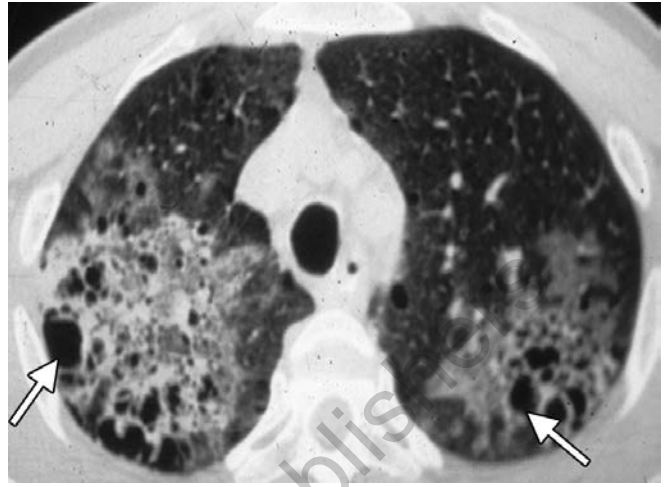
HRCT through the upper lung zones showing a dense opacity in the right upper lobe, ground glass opacities in the left upper lobe, small and large (arrows) cysts in a patient with *Pneumocystis jirovecii* pneumonia
